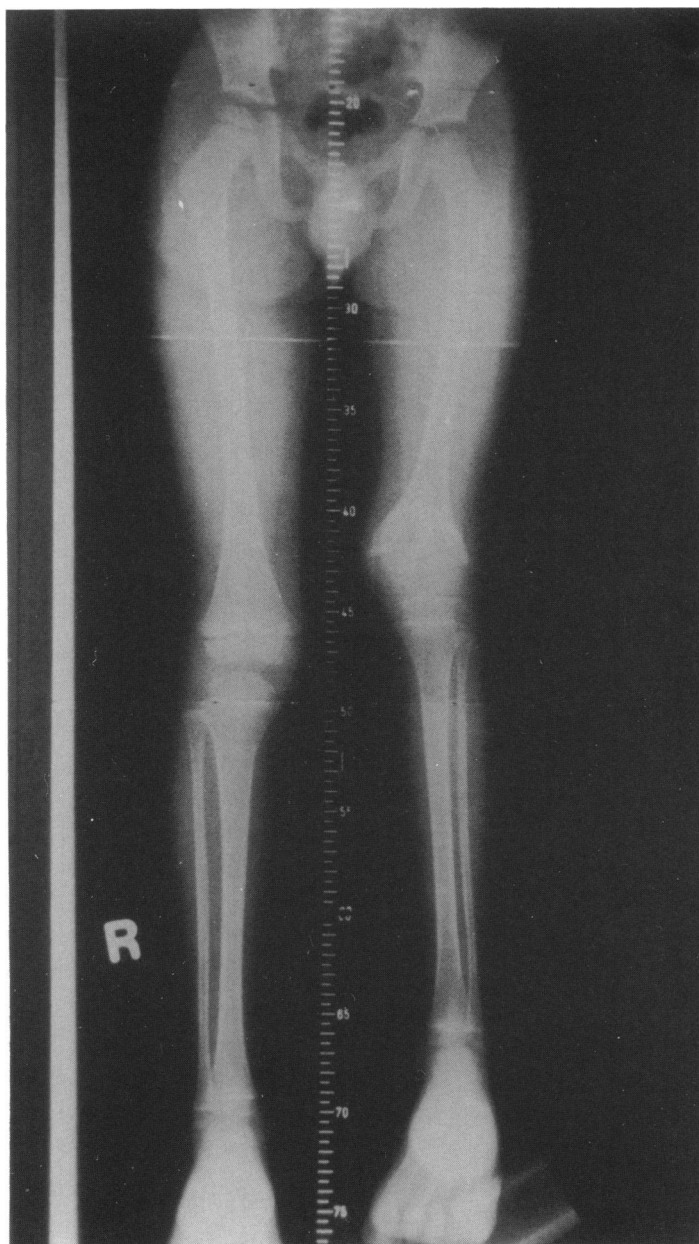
X-ray shows leg length discrepancy of 10 cm. Reproduced by permission from Atar, D. et al.: Treatment of complex limb deformities in children with the Ilizarov technique. *Orthopedics* 14(9): 961-67, 1991.
